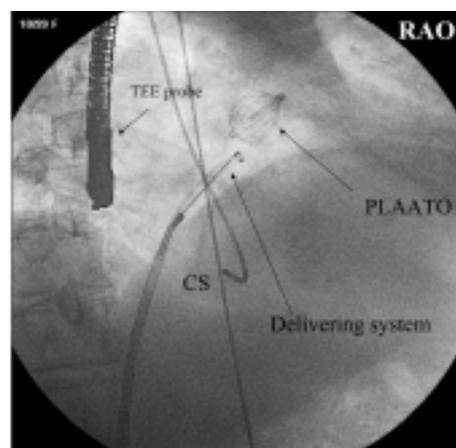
Fluoroscopic right anterior oblique (RAO) image of PLAATO releasing. It is recognizable the specific delivery system and the device in the left atrial appendage. After this definitive release the device cannot be recaptured. CS = coronary sinus; TEE = transesophageal echocardiography.
